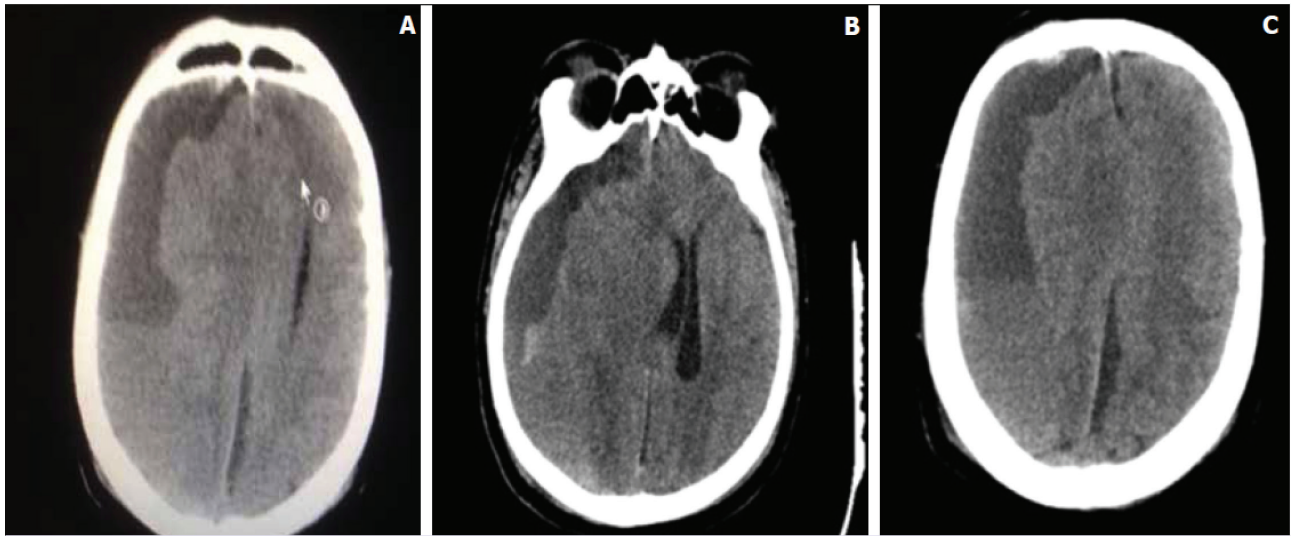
(A, B, C) Preoperative CT showed a subdural hematoma with midline shift.
